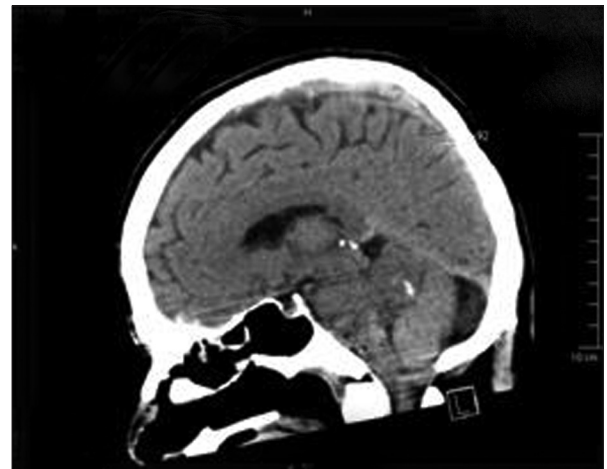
CT scan (sagittal reformat) shows mass in the right cerebellar lobe. Note calcific focus within and pineal and mamillary body calcifications
